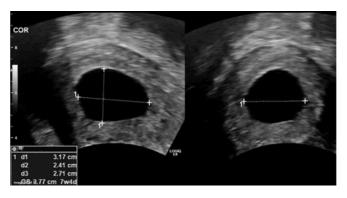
Empty gestation sac. Note that a mean sac diameter is calculated from three planes of the sac, and divided by 3. A mean sac diameter >25 mm without evidence of fetal pole or yolk sac is definitive for failed pregnancy. From Figure 26.3 of Scoutt LM, Hamper UM, Angtuaco L, eds. *Ultrasound*. Oxford, UK: Oxford University Press; 2017.
